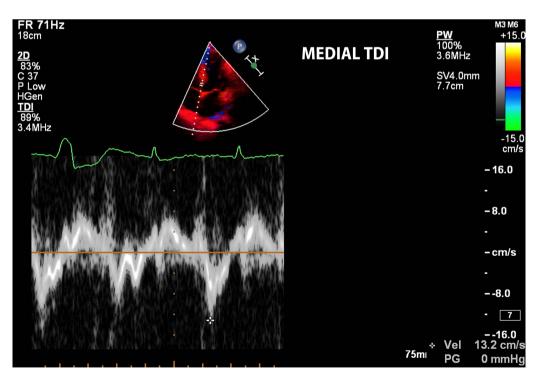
Tissue Doppler imaging showing normal medial annular velocities.
